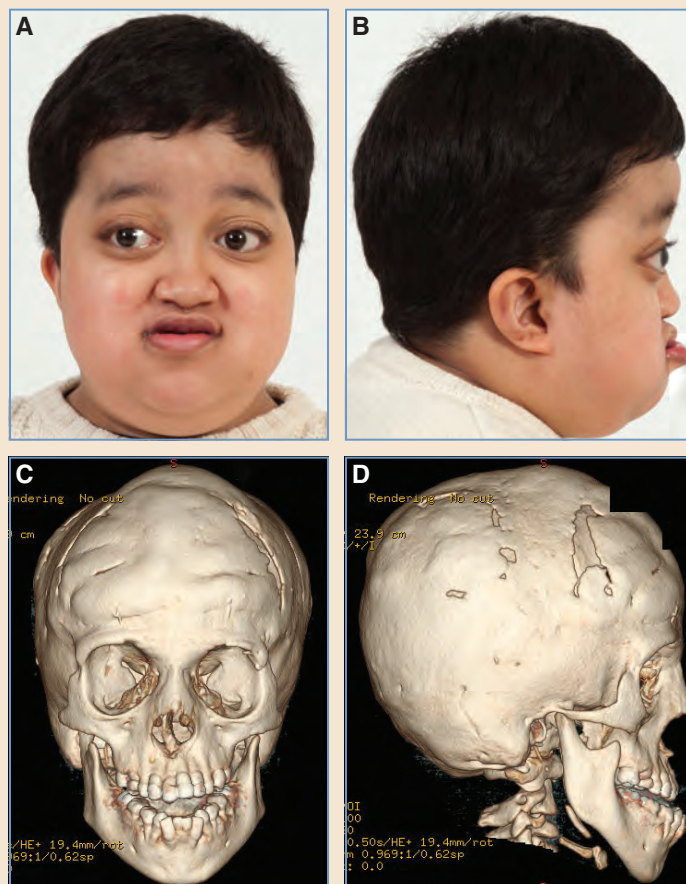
A and B, This 8-year-old boy has Crouzon syndrome, with severe exorbitism, midface retrusion, and mild turribrachycephaly from bicoronal synostosis. C and D, CT images reveal evidence of previous cranioorbital reshaping.
